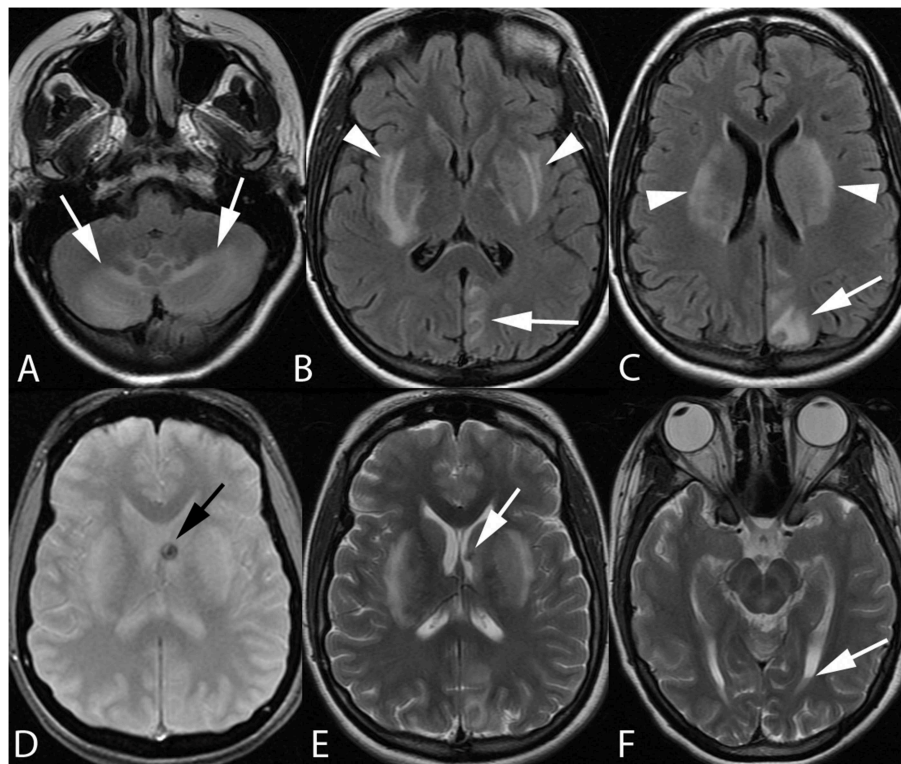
Twenty-one-year-old pregnant woman with eclampsia. Axial FLAIR images (A–C) demonstrate bilateral cerebellar hemisphere and vermis (arrows, A), bilateral lentiform/caudate and capsular (arrowheads, B,C), and left parieto-occipital edema. Axial GRE (D) and T2-weighted (E,F) images reveal focal hemorrhage within the left caudothalamic groove (arrow, D,E) extending to the left lateral ventricular body with a small hematocrit level within the left occipital horn (arrow, F) from intraventricular extension of hemorrhage.
